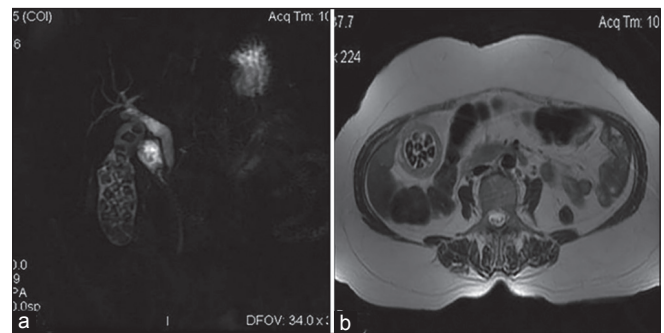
Magnetic resonance cholangiopancreatography image showing cholelithiasis (a) and axial T2-weighted image showing cholecystitis with cholelithiasis (b)
